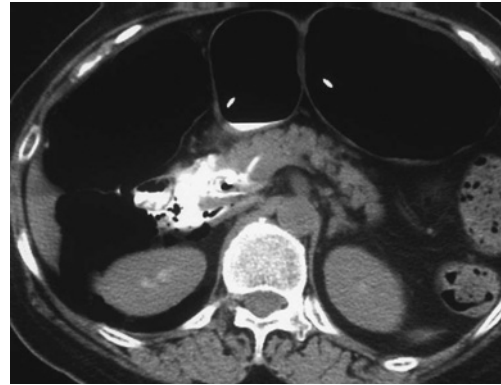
CT scan after ERCP showed extravasation of contrast medium and widespread pneumoretroperitoneum.
